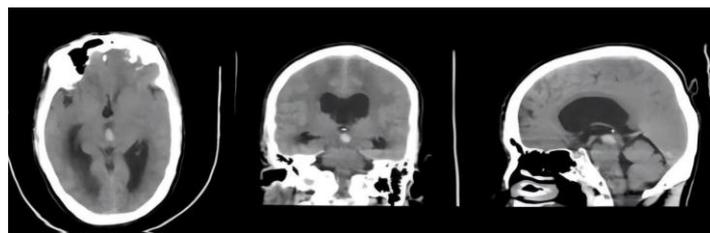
CT scan of the head of case 2 shows a high-density lesion near the midline of the midbrain tegmentum
